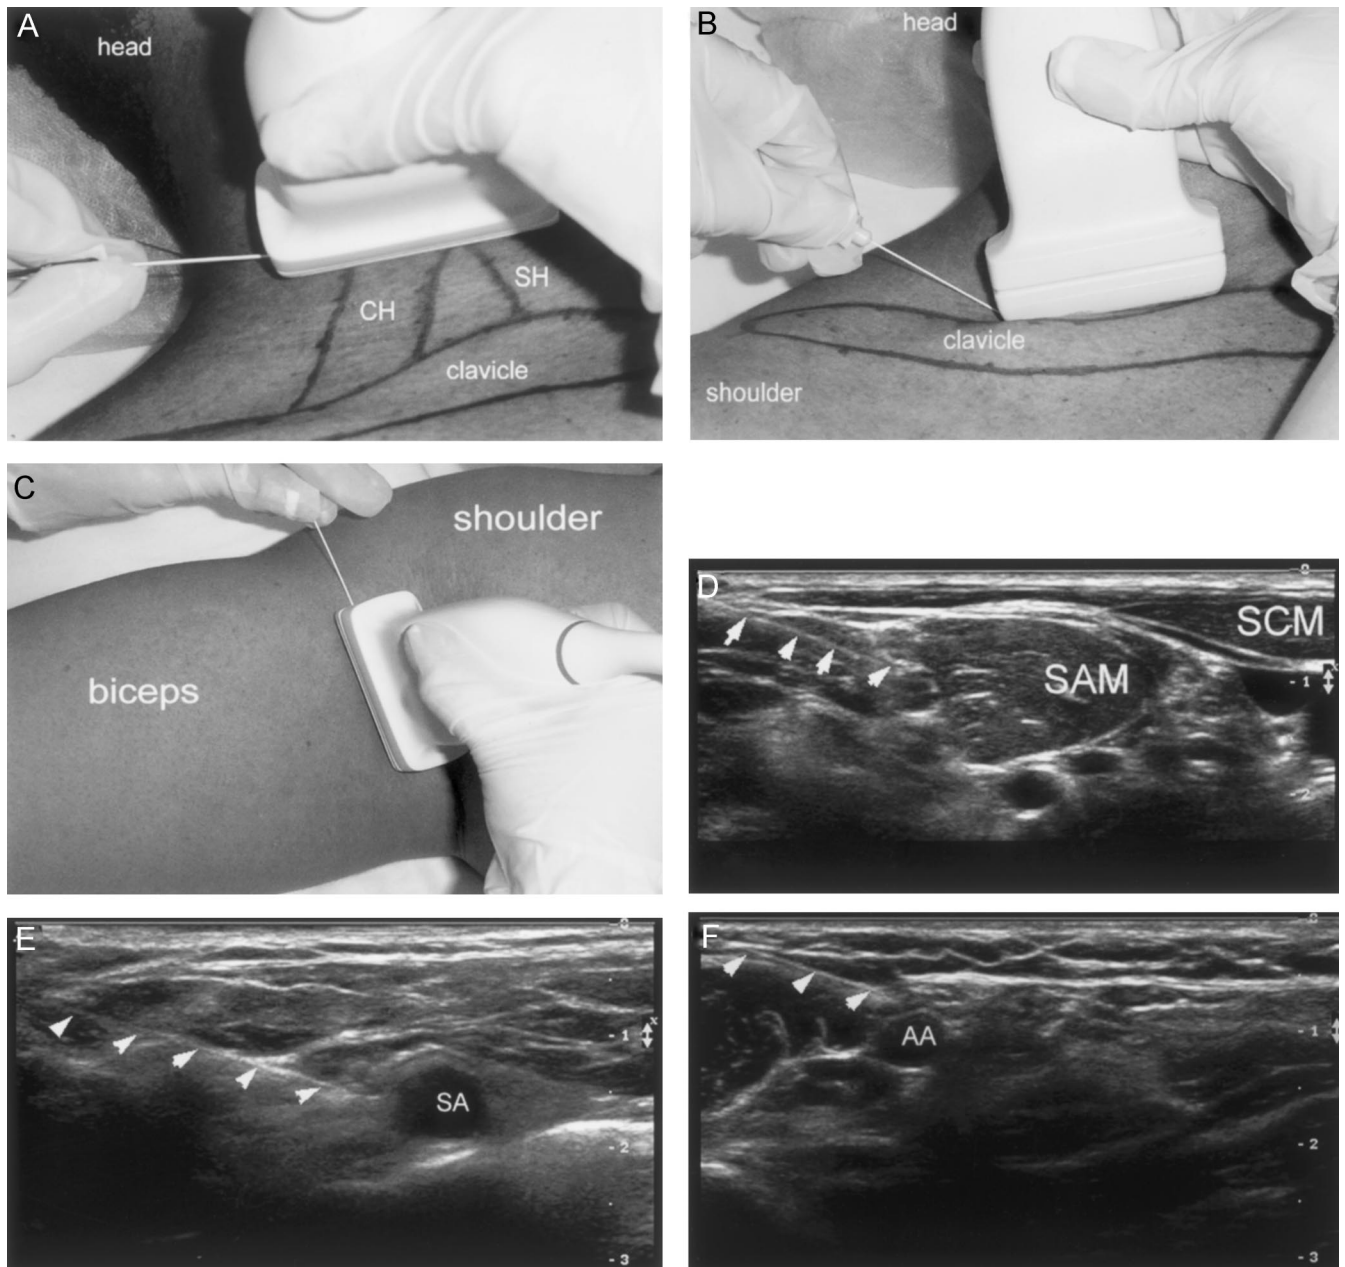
(A–F) The ultrasound-guided needle advancement technique, showing one hand holding the probe and one hand holding the insulated needle in the interscalene location (A) (CH = clavicular head of sternocleidomastoid muscle; SH = sternal head), the supraclavicular location (B), and the axillary location (C). In all cases, the needle is positioned at one end of the ultrasound probe and passed in-line with the ultrasound beam *i.e.*, in the same plane. Sonogram of the needle (arrows) in contact with the brachial plexus in the interscalene (D), supraclavicular (E), and axillary (F) locations. AA = axillary artery; SA = subclavian artery; SAM = scalenus anterior muscle; SCM = sternocleidomastoid muscle.
